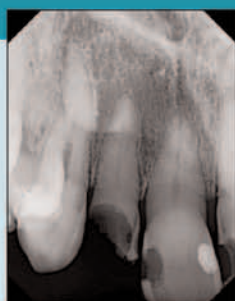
Pre-op periapical radiograph shows the extent of the decay and the sub-gingival nature of the distal margin.
